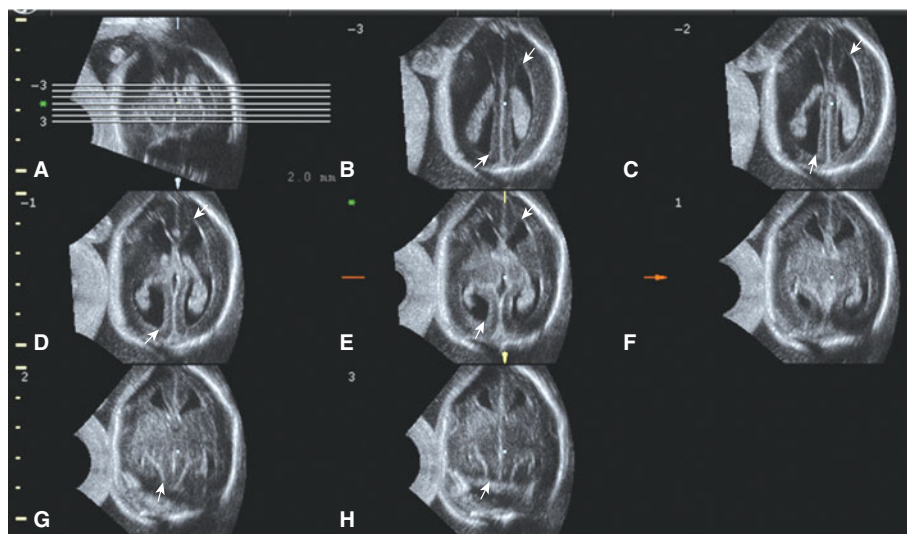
A volume of the head of a fetus with Chiari II malformation is displayed using the tomographic feature of 3D US. Using this format, most of the cranial sonographic findings that help in the diagnosis of a Chiari II malformation are seen. (A) Coronal section showing the localization of the axial sections displayed in (B)–(H); the sections are 2 mm apart. (B)–(F) Mild ventriculomegaly is present. The ventricular point sign (*small arrow*) is evident in the posterior horn of the lateral ventricle, as well as in the anterior horns (*arrow*). The head displays the “lemon” sign. The dot is over the interventricular cyst. (G), (H) Beaked tectum at the arrow. The cerebellum is not seen in this fetus, most likely because it has herniated through the foramen magnum.
